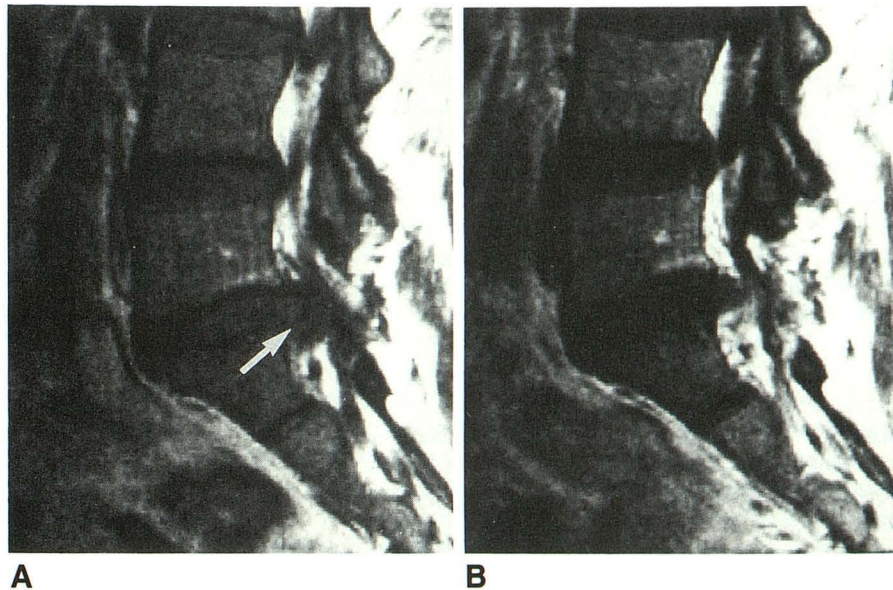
A, Sagittal T1-weighted (500/20) pre-contrast MR image shows a very ill defined anterior epidural soft-tissue mass at L4-L5 level (arrow), with slight mass effect upon the anterior thecal sac. Differentiation of scar from disk is not possible.
